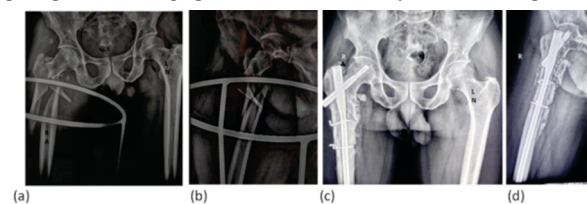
Radiographs of a 50-year-old male patient with comminuted intertrochanteric fracture: (a) pre-operative radiograph in AP view, (b) pre-operative radiograph in lateral view, (c) postoperative radiograph AP view at one-year of follow-up, and (d) postoperative radiograph in lateral view at one-year of follow-up
